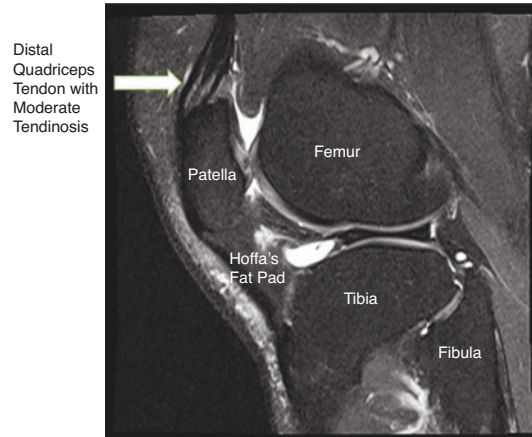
MRI – moderate tendinopathic changes quadriceps tendon
